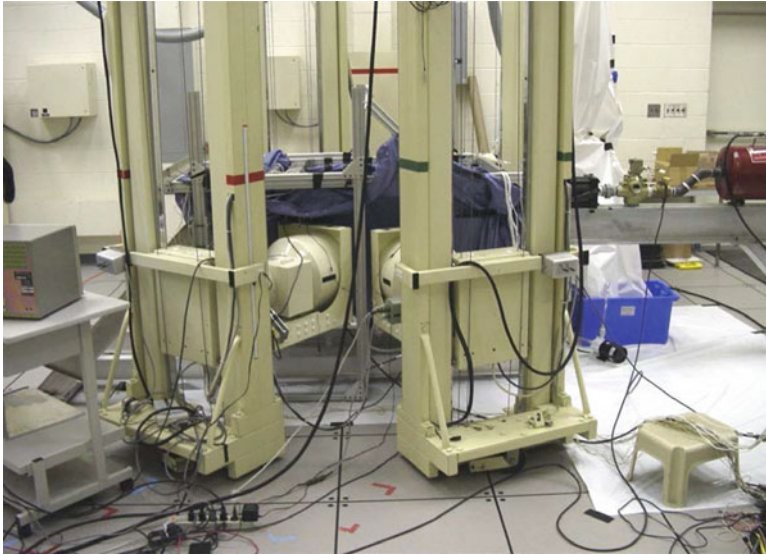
Photograph of the biplanar X-ray setup (courtesy of Dr. Warren Hardy)
